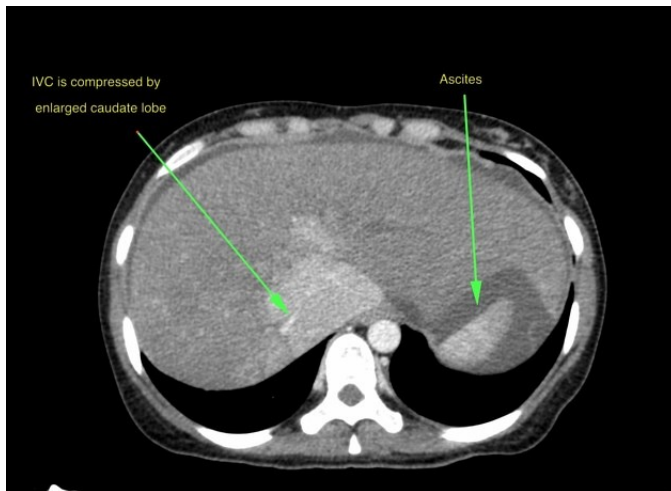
Budd-Chiari Syndrome in a native CT (45)
